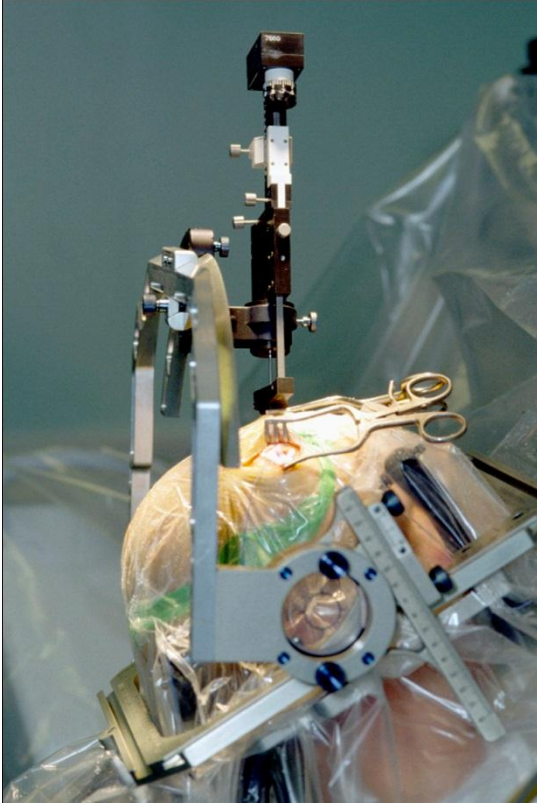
A parkinsonian patient undergoing a subthalamic implant procedure with a framed stereotaxy. Newer methods of such implantation procedures don't involve such frames, and thus are called frameless stereotaxy. Here the precise location of an electrode tip is determined by pre-operative or intra-operative MRI. An even newer method is intra-operative 3D USG. (image from Wikimedia Commons)
